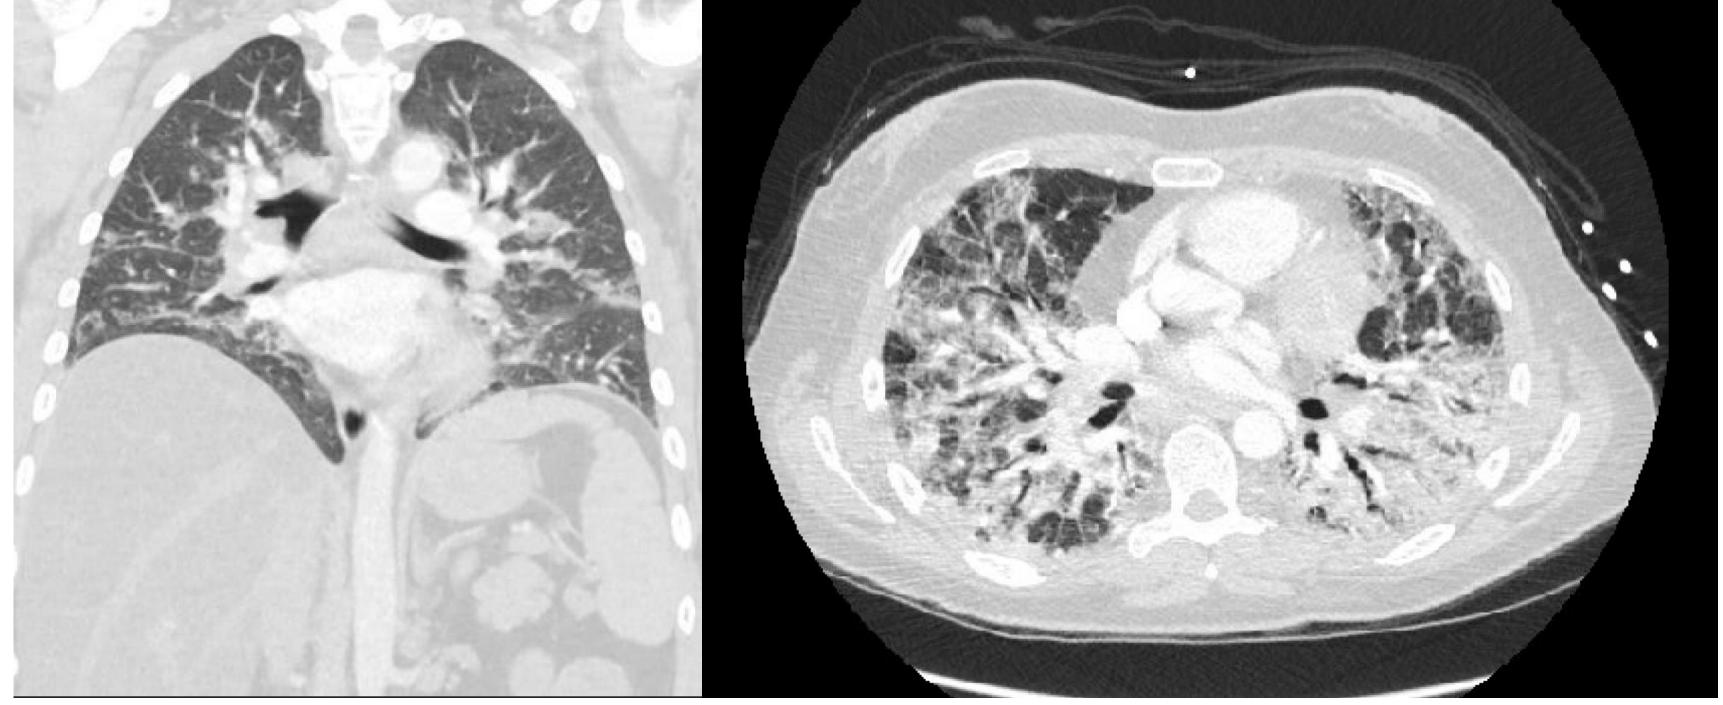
Image C/D: CTA chest on admission with diffuse ground glass opacities consistent with rapidly progressive interstitial lung disease.
